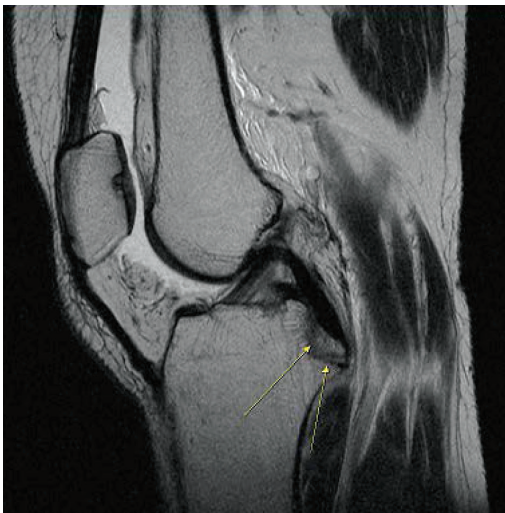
Left knee MRI (January 20, 2018).
